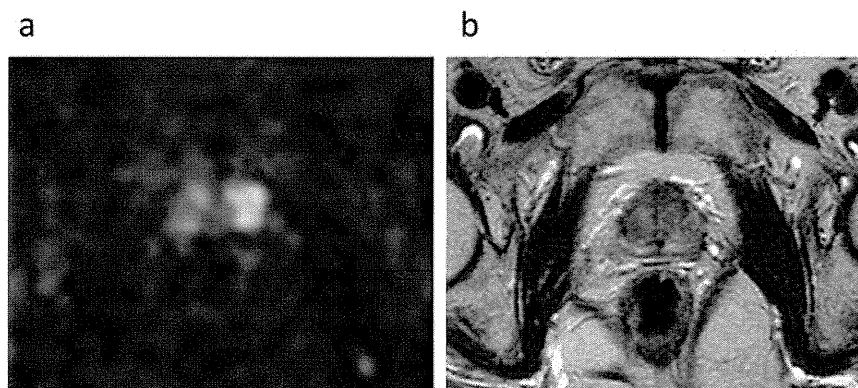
A 74-year-old man with prostate cancer in the left peripheral zone. Prostate-specific antigen was 1.63 ng/ml before radiation therapy (160 ng/ml before all therapy) and the Gleason score was 8. T2-weighted image shows focal low-signal intensity in the left peripheral zone of the apex (a), and diffusion-weighted image shows focal high-signal intensity in the same region (b). The apparent diffusion co-efficient value of the lesion was  $0.642 \times 10^{-3} \text{ mm}^2/\text{s}$ .
